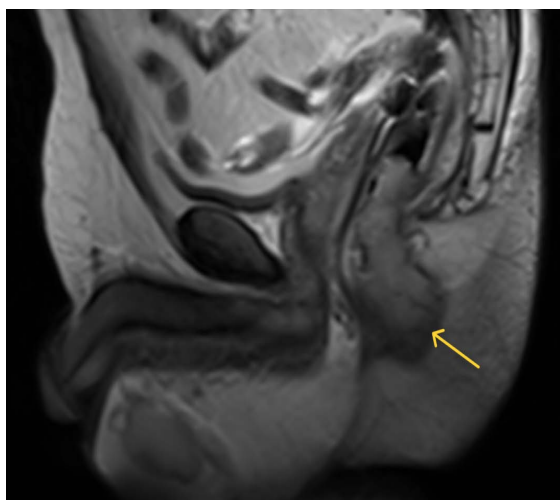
T2 MRI (Sagittal) showing lobulated enhancing mass measuring nearly 7 cm in length by 3 cm in maximum width which appears to be sessile along the posterior rectal wall although may have a pedunculated component along the anterior mucosa.
